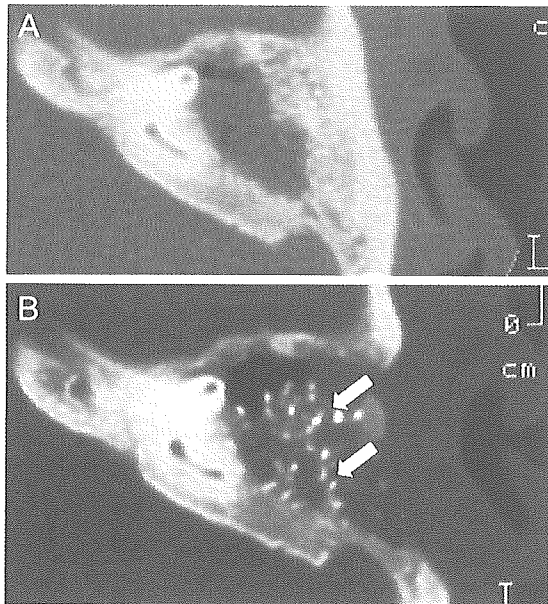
Computed tomography scan images of case 5, before and after surgery. (A) There is no aeration in the mastoid cavity before the operation. (B) Eight months after the first-stage operation, aeration is partially recovered, but the pneumatic air cells are not regenerated by the three-dimensional hydroxy apatite (arrows).
